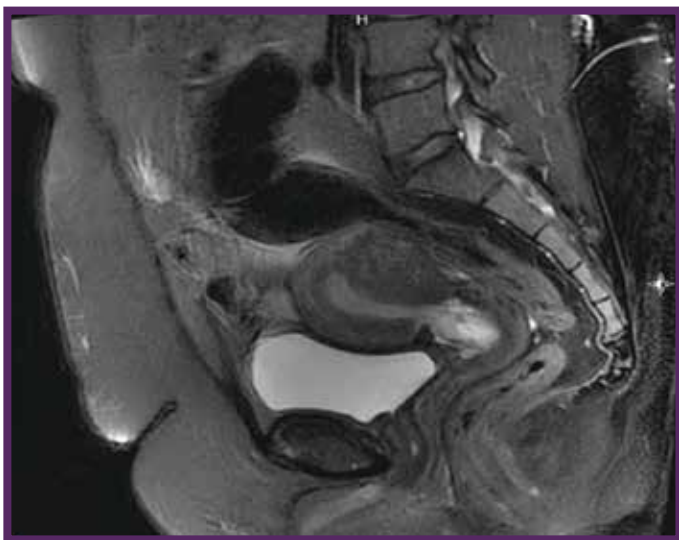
MRI image showing a single Gestational sac is seen in the cervical canal, not attached to and distal to the level of previous C-section scar at the lower anterior uterine segment, almost protruding through the external os.
